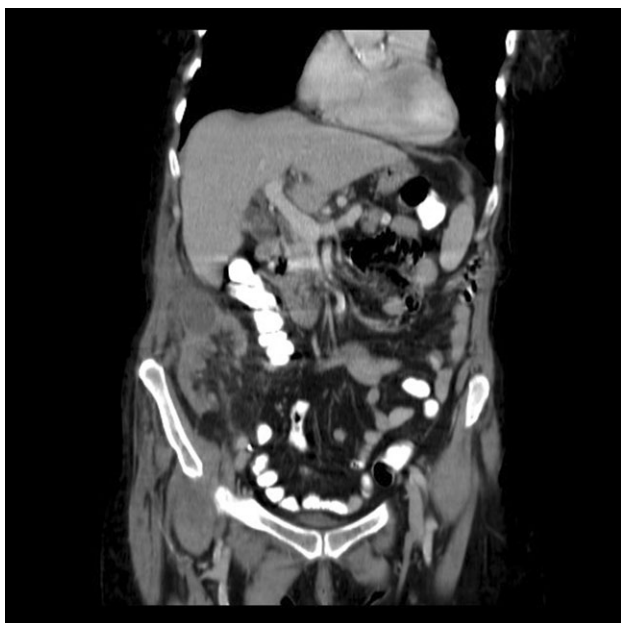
CT images of the transplanted kidney obtained at admission. Coronal image depicting a 3 cm round hypodense mass at the upper pole of the transplanted kidney.
